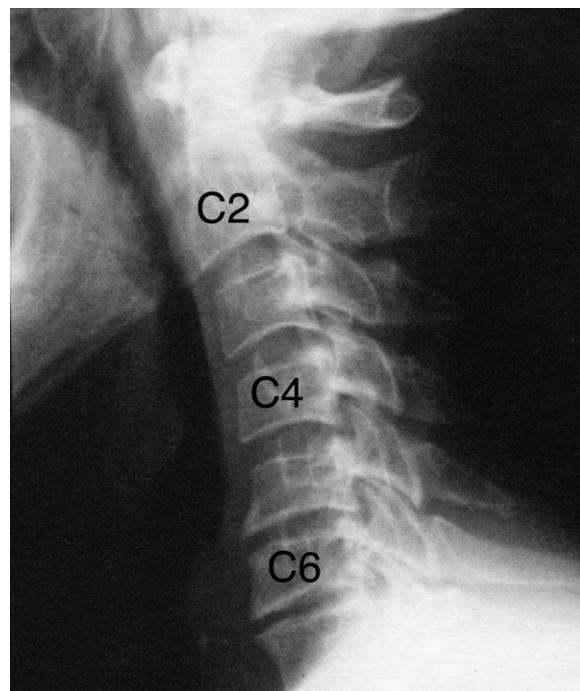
Cervical spine extension plain X-ray image. Note the loss in the C5-6 and C6-7 disc space heights as compared to upper disc heights. The C6 vertebral body height appears to be slightly less than that of the adjacent vertebral body heights suggesting a past compression fracture at C6.
